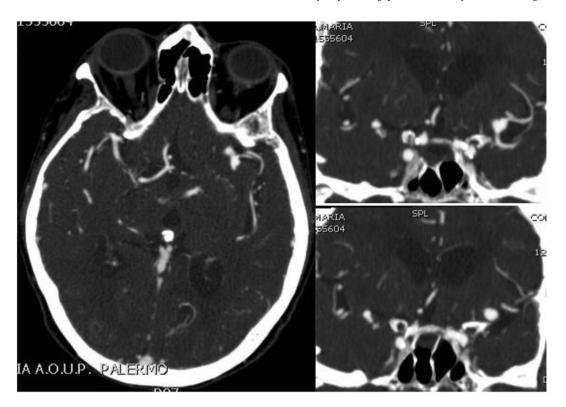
CT angiography showing the large, irregular, sacculated, unrupted right MCA biforcation aneurysm
